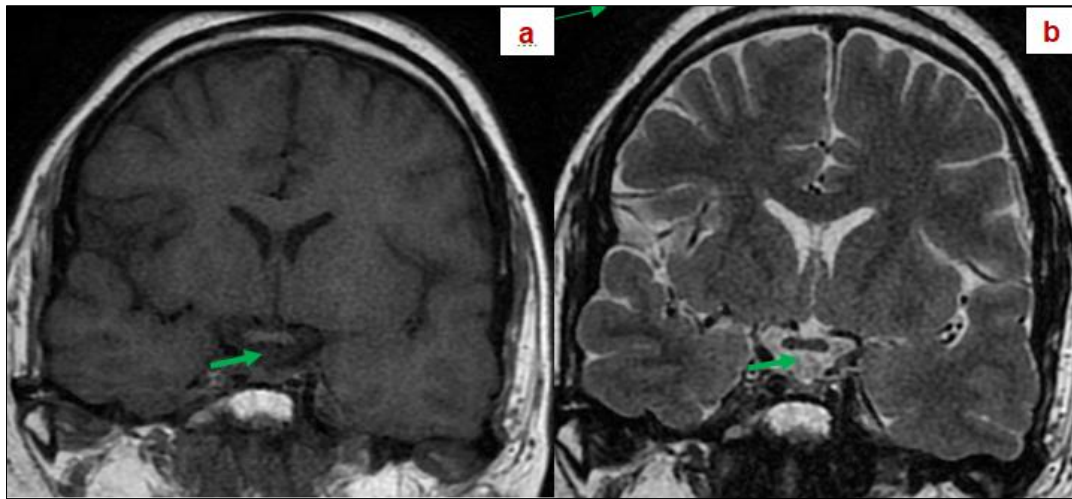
Coronal T1 (a) and T2 (b) weighted MRI sequences demonstrating an interrupted pituitary stalk (arrow).
